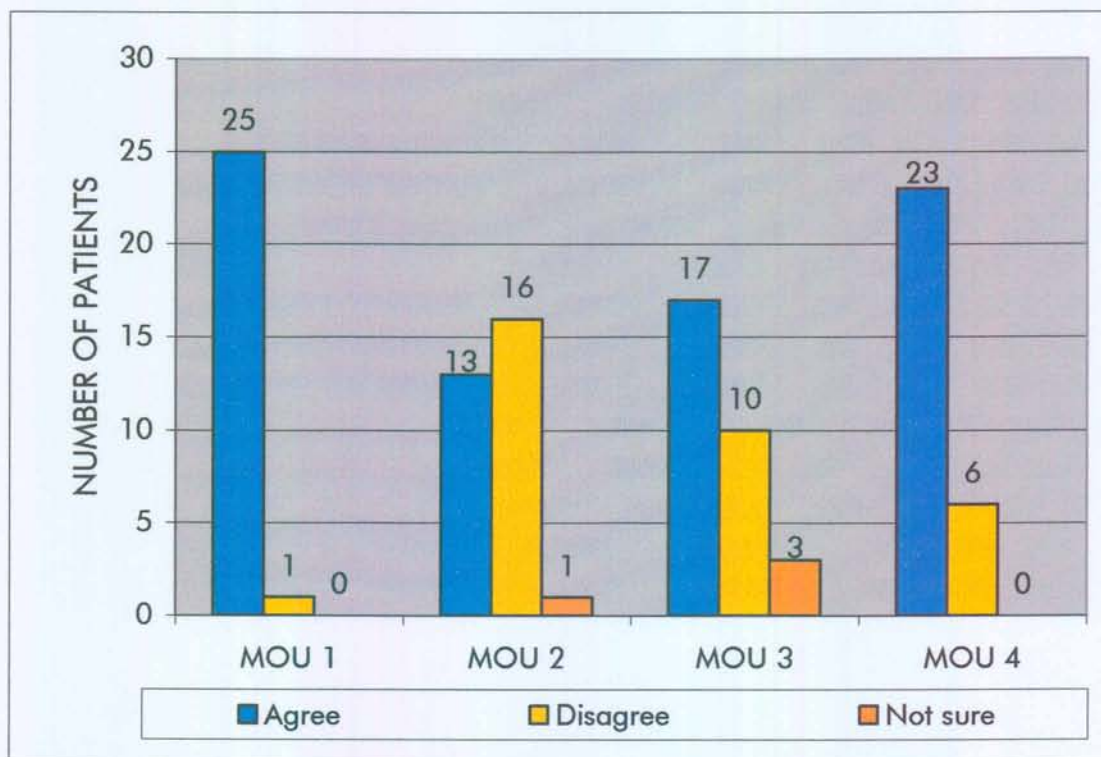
PATIENTS TREATED WITH RESPECT (n=30)
